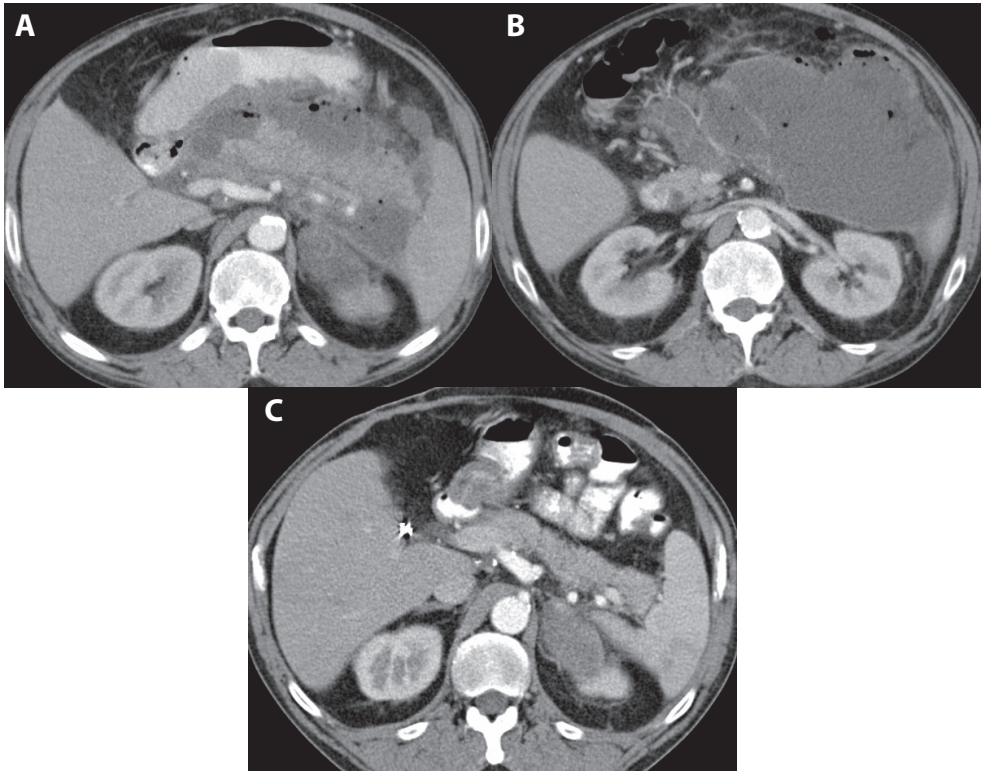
Contrast-enhanced computed tomography (CT) of a patient with acute pancreatitis 22 days after onset of symptoms, A with normal enhancement of the pancreas and B surrounded by a large heterogeneous and encapsulated fluid collection with gas bubbles suggesting secondary infection. Some would call this 'necrotizing pancreatitis', but others would call it 'interstitial pancreatitis' because there is no evidence of pancreatic parenchymal necrosis (only peripancreatic necrosis). A large amount of fat necrosis was debrided during operation. C Follow-up CT 6 months after operation reveals a normal enhancing pancreatic parenchyma
